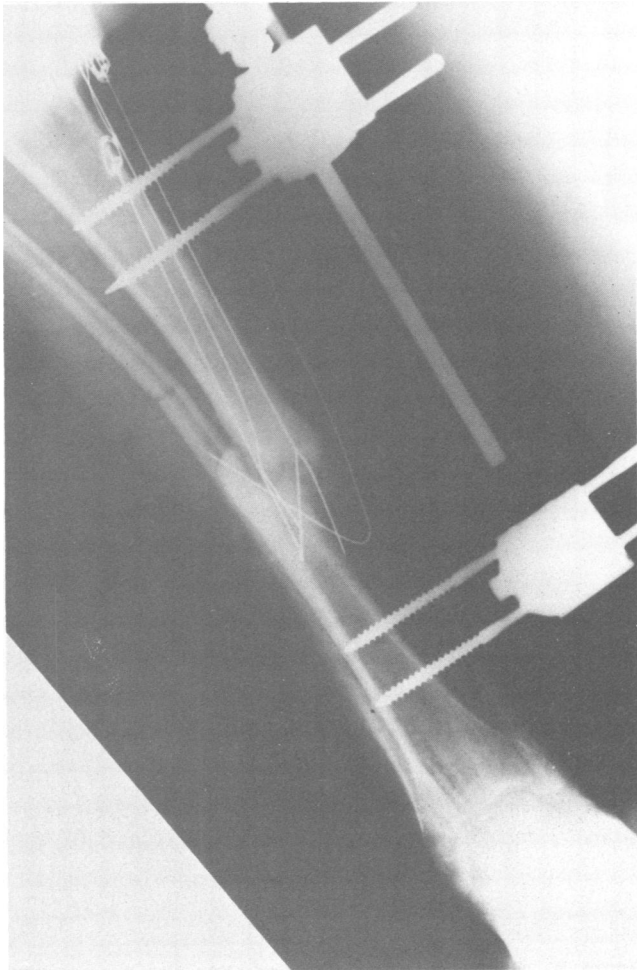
Photograph of x-ray showing Wagner apparatus and electrodes in place.
